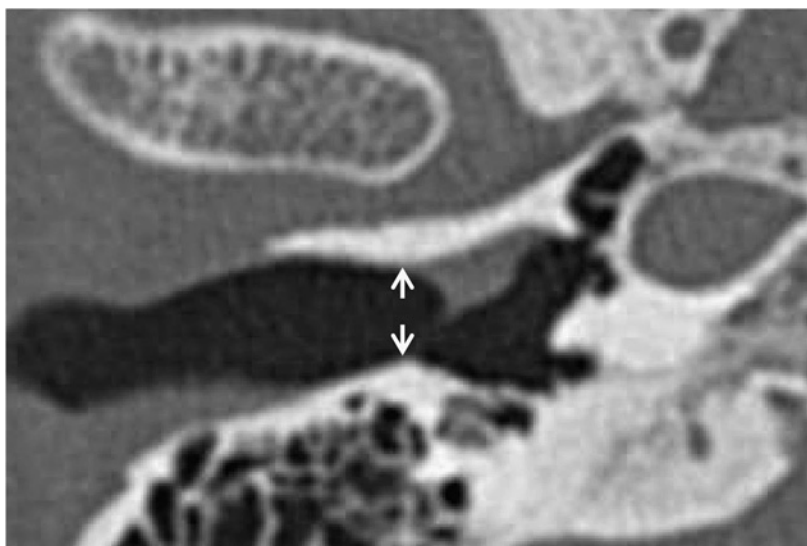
CT image (horizontal plane, right ear). Bony stenosis of the external auditory canal (arrow).
